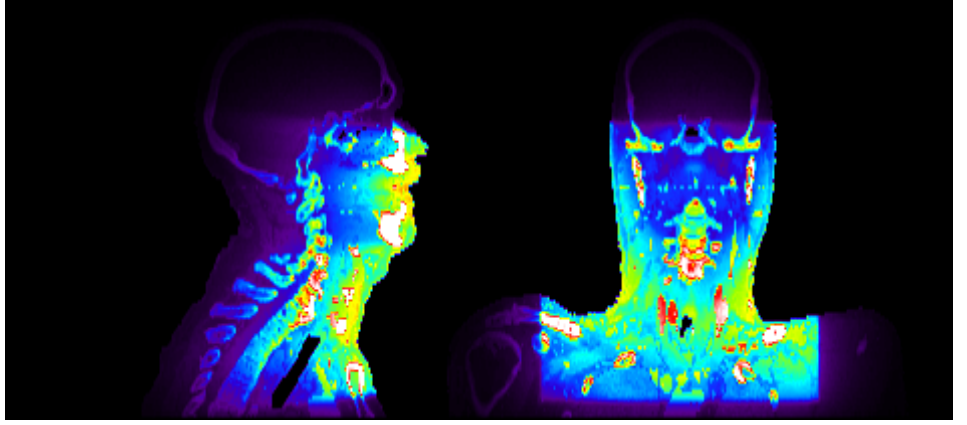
Central slices for Pat. A for a single beam at 0° . The slice positions are marked in the CT-slices shown in (n) - (p).
